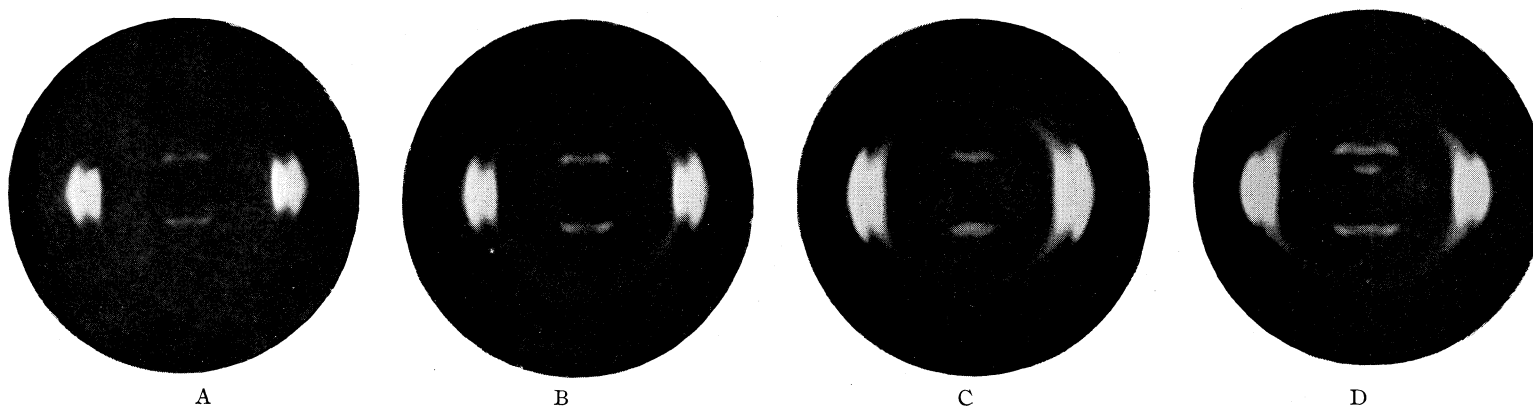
X-Ray patterns of oriented polyamides and copolyamides of the 10-10:6-10 series: A, 100% 10-10; B, 70% 10-10 and 30% 6-10; C, 55% 10-10 and 45% 6-10; D, 100% 6-10.
